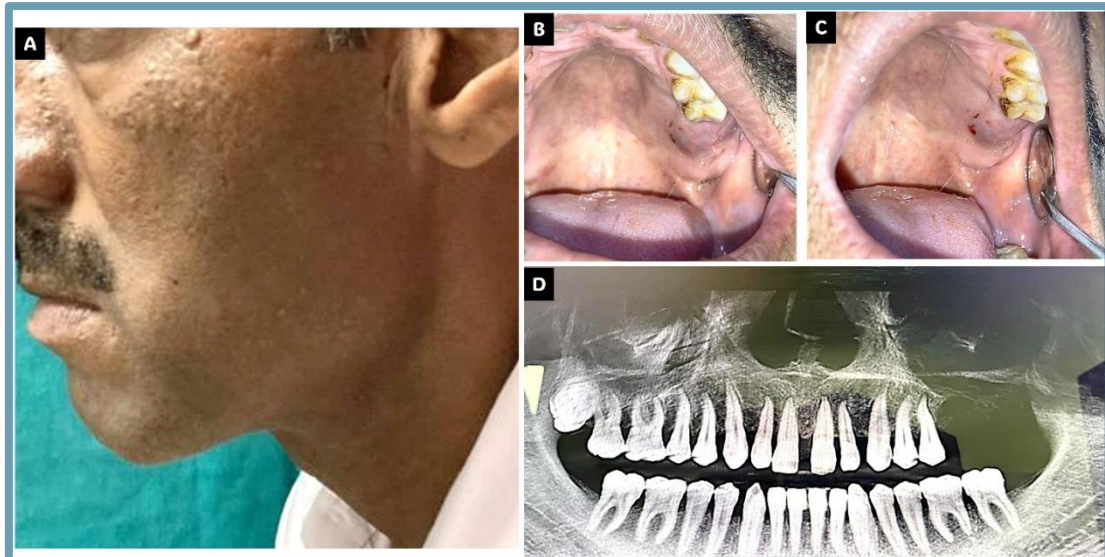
(A) Lateral view of the face (B) Intraoral view showing maxillary tuberosity region lesion (C) Intra oral view showing palatal aspect of the lesion (D) Orthopantomograph showing a lesion on the left maxilla
